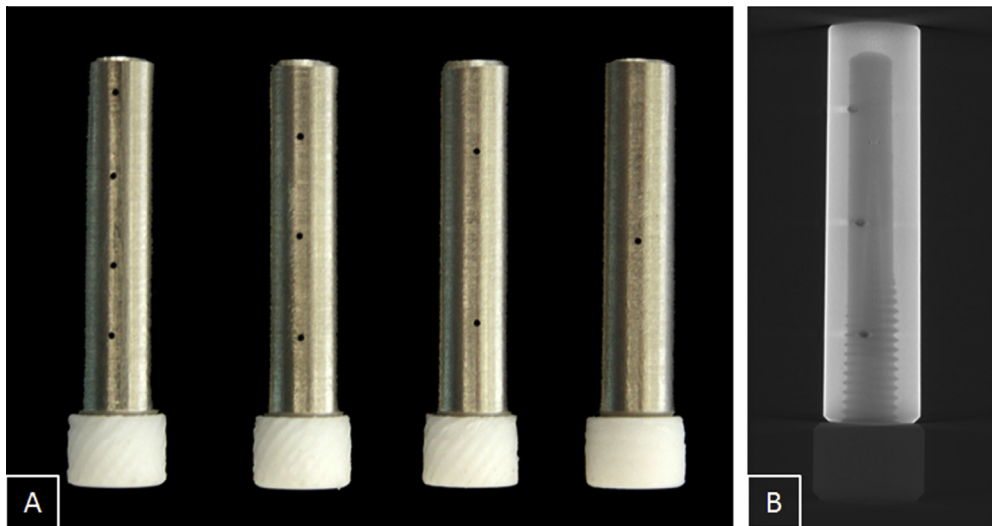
(A) Lateral image of the four different models of implants tested. Note the equidistant through pinholes. (B) X-ray microtomography of one of the implants (6 pinholes) to show the hollow interior and the screw-in PTFE cap. Note the equidistant through pinholes.
